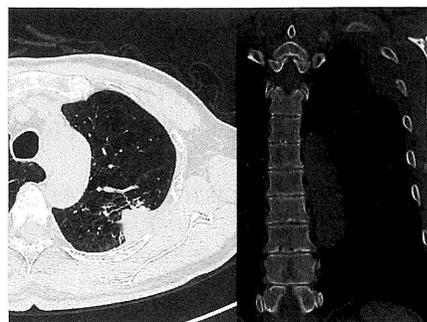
Case 2. Computed tomography shows a tumor in the left upper lung lobe that has invaded the chest wall.
